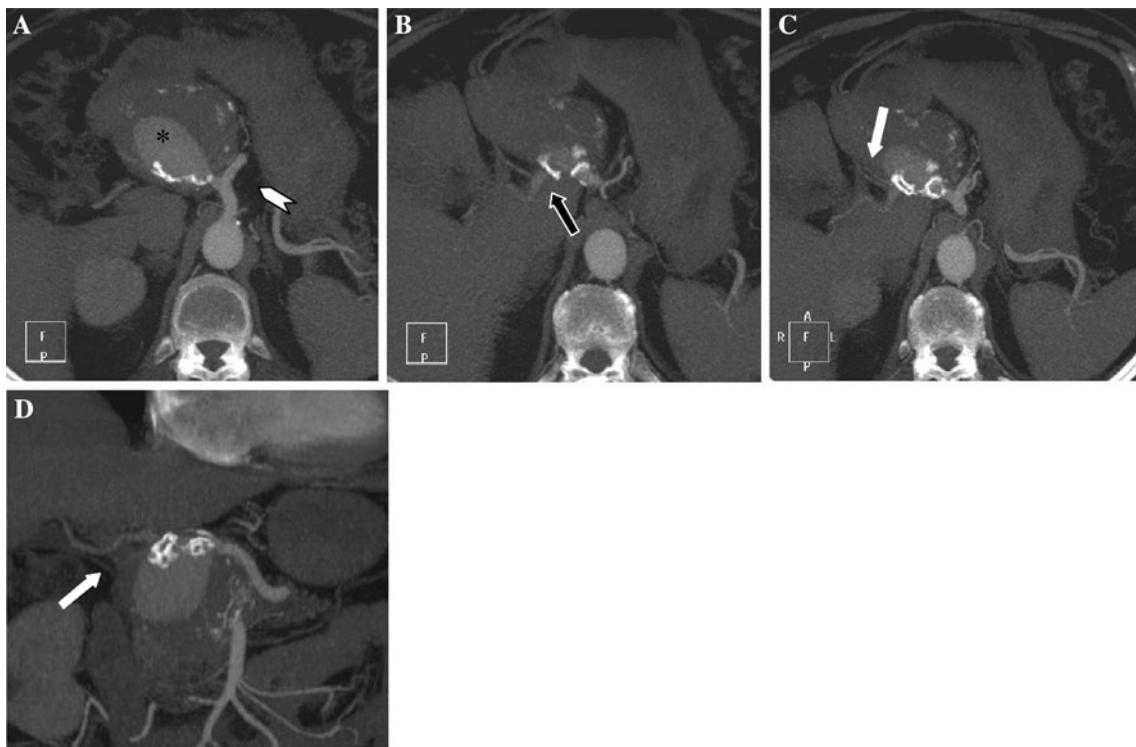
CTA scan (maximal intensity projection [MIP]) showing a large aneurysm (*) of common hepatic artery and a virtual neck with the splenic artery (white head arrow) (A) and short neck with proper
